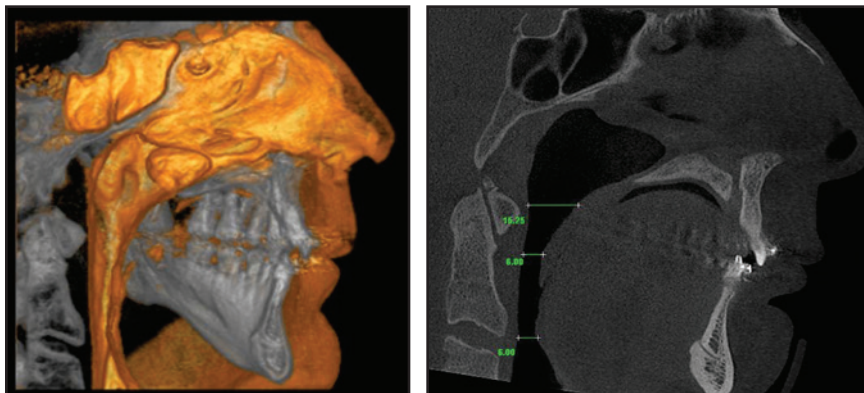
CBCT after surgery, showing more than 100% increase in upper airway diameter.
